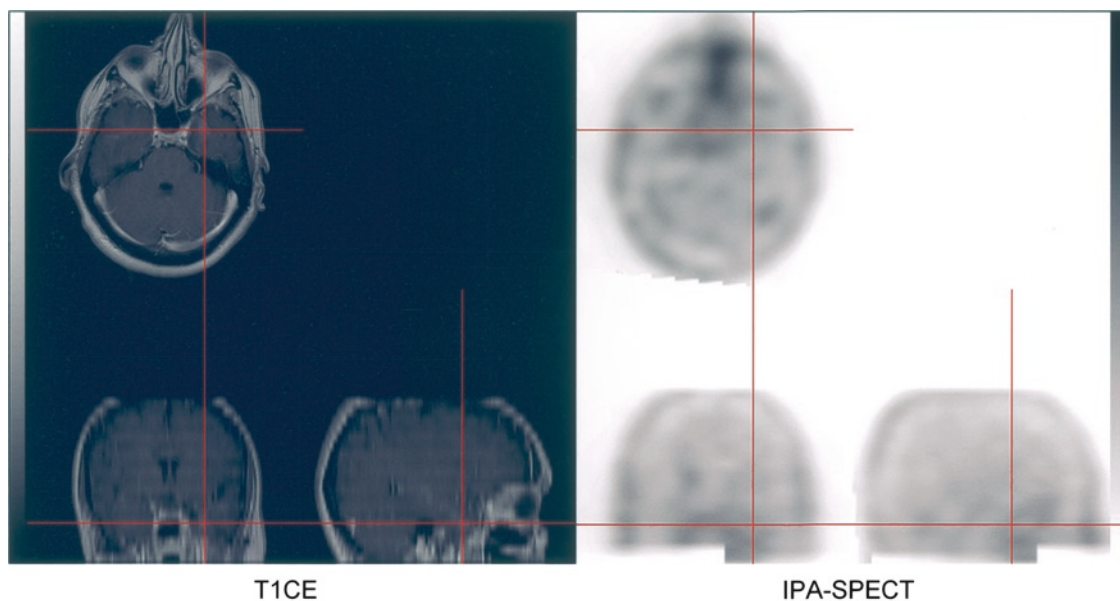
True negative IPA-SPECT in left mesiotemporal cortical dysplasia. IPA-SPECT showed no increased uptake
